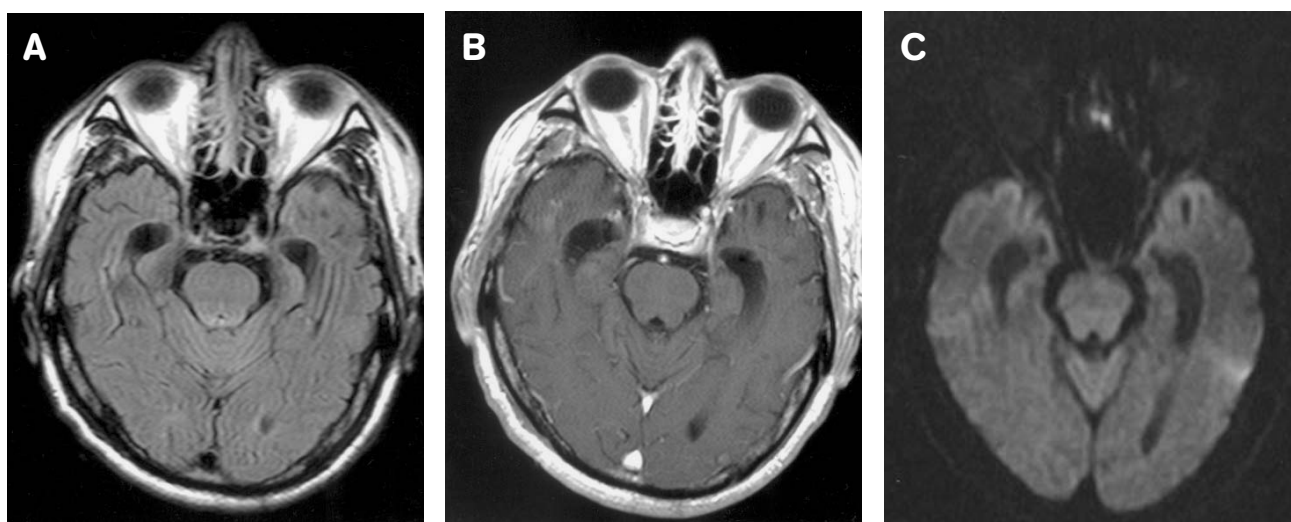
Eight months after admission. (A) Axial FLAIR imaging and (B) T1-weighted imaging post-contrast and (C) Diffusion-weighted imaging all showed normal appearance over bilateral mesial temporal regions.
